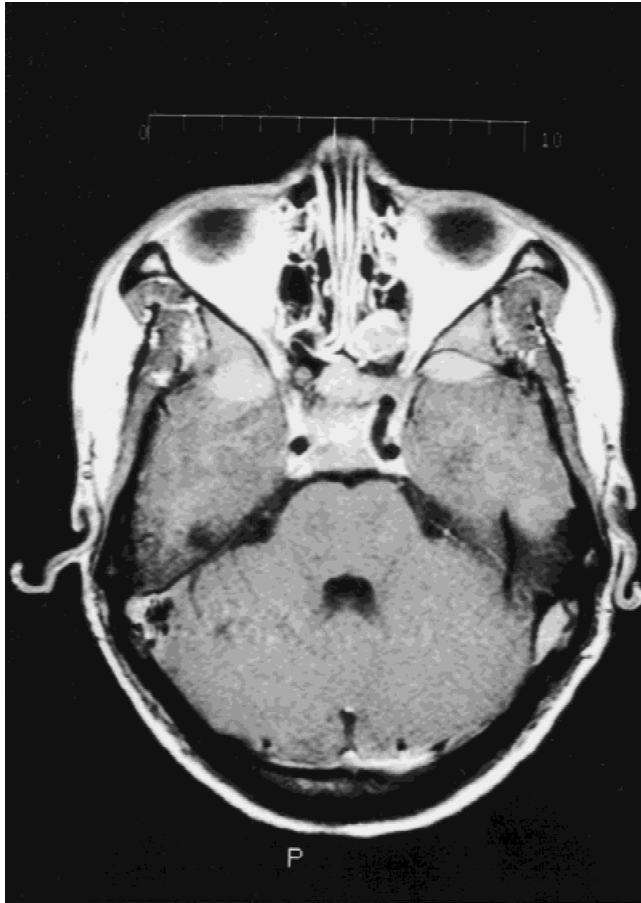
MRI from December 1995; post-contrast T1 transaxial view that reveals enhancing lenticular-shaped homogeneous soft tissue masses along the anterior aspects of the middle cranial fossae bilaterally, which demonstrate extrinsic compression on the anterior aspects of the temporal lobes.
